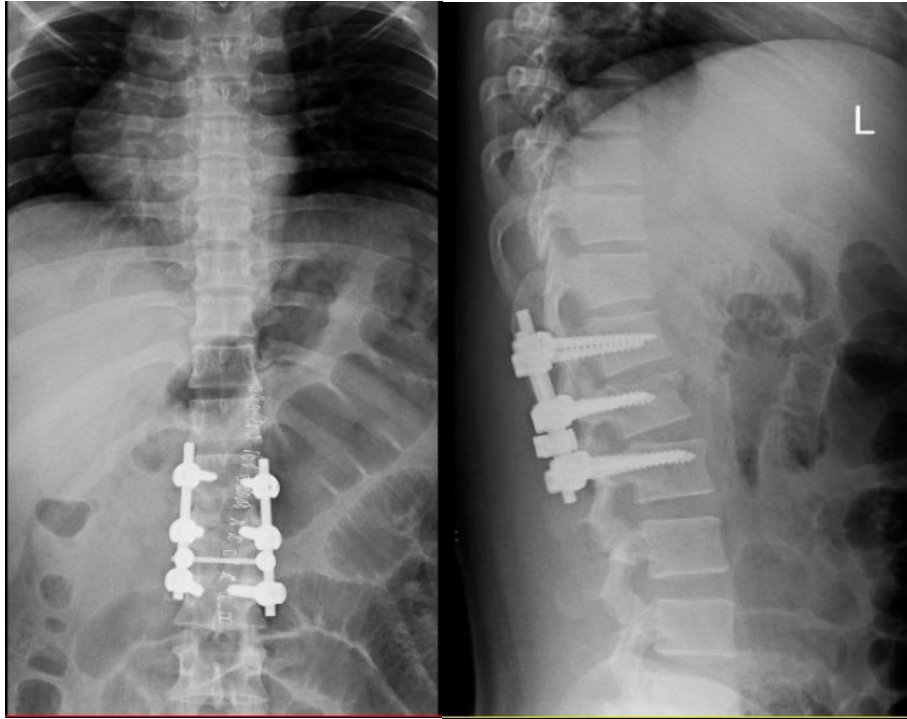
Following is the post op radiograph of the Lumbosacral vertebrae.
